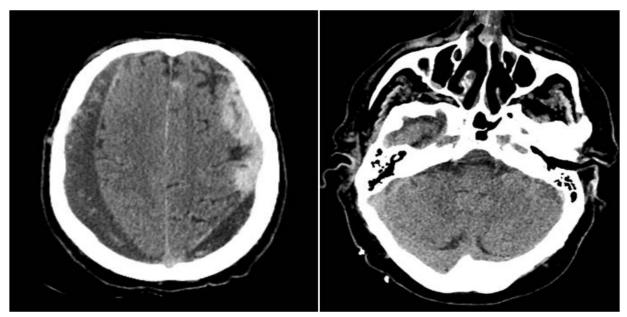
Preoperative axial non-contrast computed tomography scan showing a subdural hematomas of the two convexities of chronic gait with acute component this day measuring 18 mm. No engagement. Foci of subarachnoid hemorrhage in left upper frontal furrows. No cerebellar abnormality.
